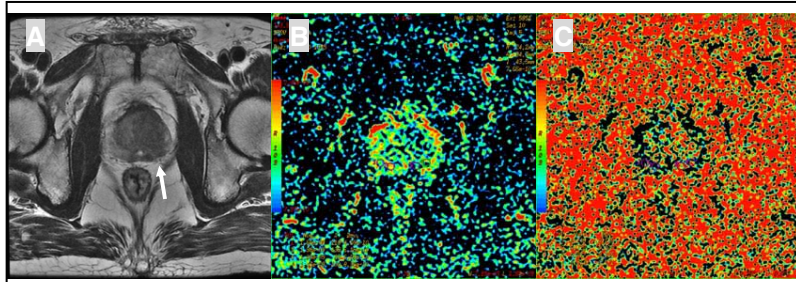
T2-weighted image (A) shows low signal intensity (arrow) of left peripheral zone in accordance with a positive biopsy result. ADC (B) and FA (C) value showing corresponding decrease in the same regions.
